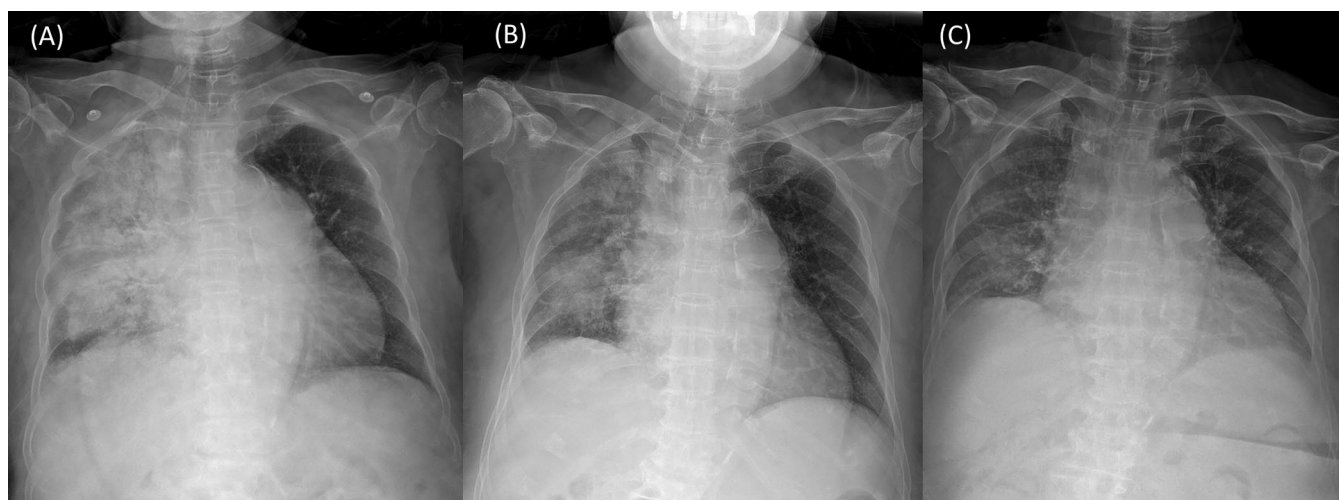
The serial chest radiographs taken after initiation of treatment. (A) Day zero of intravenous rituximab and corticosteroid administration. (B) Day 7 after intravenous rituximab and corticosteroid administration. (C) Day 21 after intravenous rituximab and corticosteroid administration
